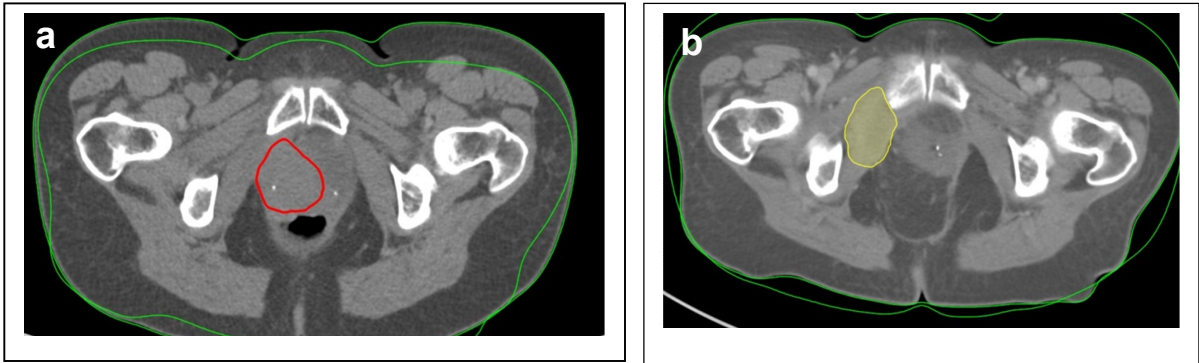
CT scans at 2 different levels through the femoral heads (a, superior section, b, inferior section). Pre-operative tumour contour (red) and post-exenterative relapsed tumour volume GTV (yellow) as outlined on Eclipse radiotherapy planning system.
